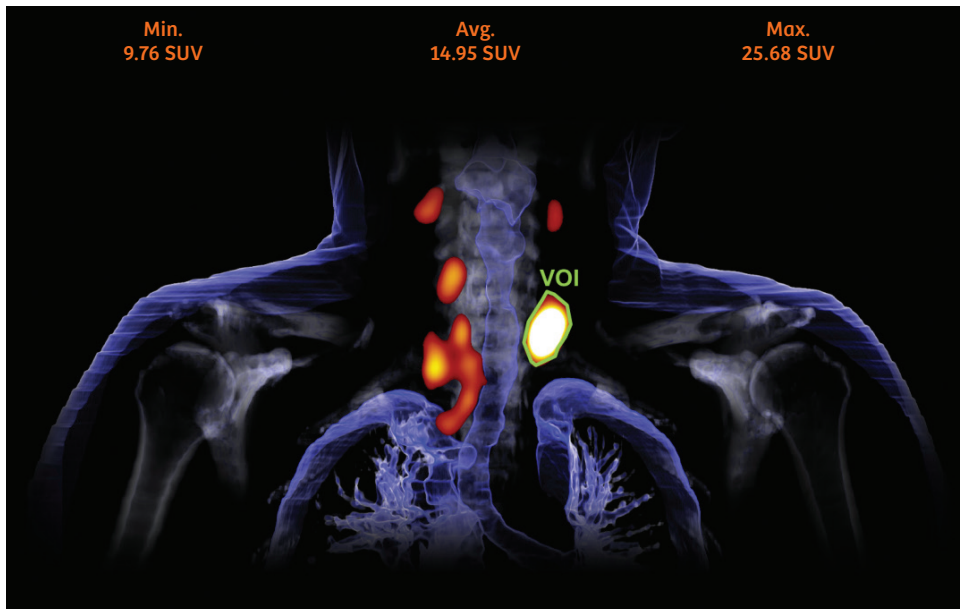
Clinical example of a patient scanned on a Symbia™ SPECT/CT system using xSPECT Quant. The image shows a ^{99m}Tc thyroid scan revealing a hyper-functioning thyroid adenoma and the standard uptake values (SUVs) for defined volume of interest (VOI).
